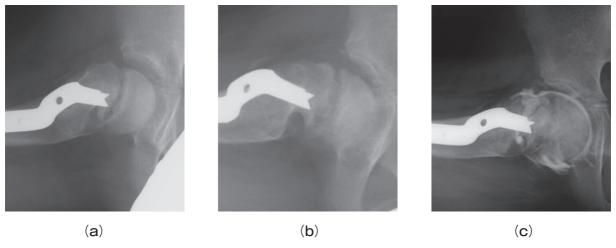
Radiographs taken during the post-operative period. a, Lateral view at 2 months (the α and β angles were 123° and 86°); b, 8 months after the osteotomy; c, Arthrogram at the time of implant removal. The bump was gradually remodeled. One year after surgery, an arthrogram was performed and an implant was placed. The impingement of the labrum against the femoral bump is shown (the α and β angles were 84° and 76°).
